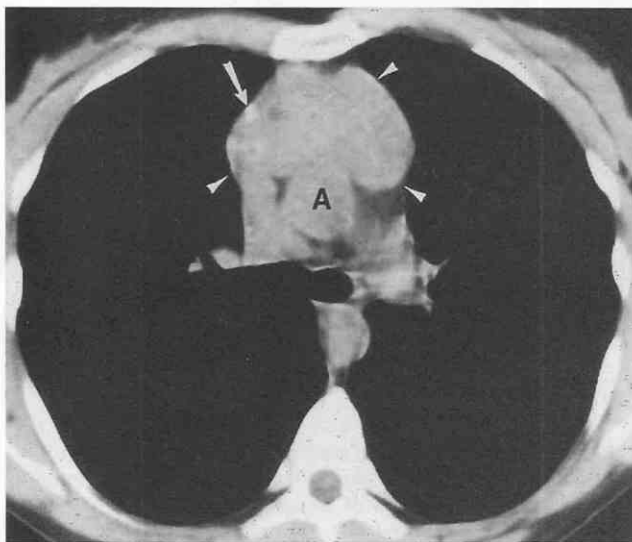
Hodgkin's lymphoma in a young woman. CT shows a homogeneous, anterior mediastinal mass (arrowheads). A punctate calcification (arrow) can be seen within the mass. A, ascending aorta.
